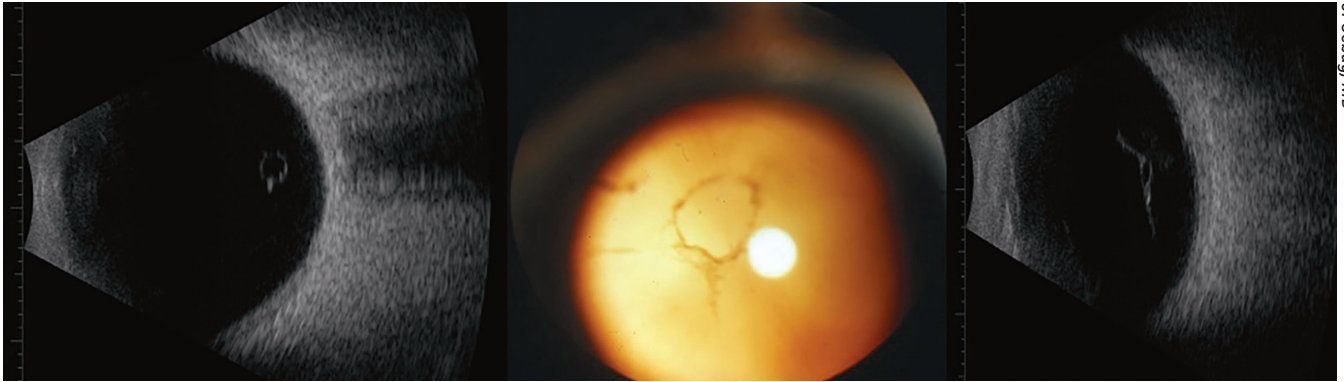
Weiss Ring imaged by ultrasonography (left) and fundus photography (center). Image on the right shows Weiss Ring within the detached posterior vitreous cortex.
